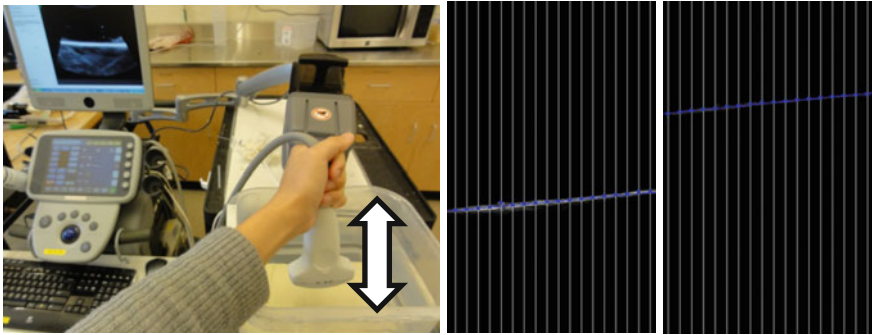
Moving the transducer up/down repeatedly for acquiring tracking and imaging data for temporal calibration (*left*). Position of the water tank bottom is automatically detected in the ultrasound image and used as position signal for the image data. Position of the water tank bottom is shown for the *top* and *bottom* positions (*center, right*)
